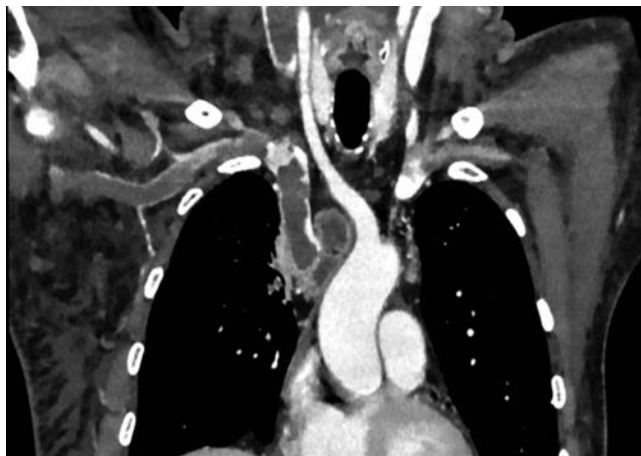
Preoperative CT showed complete right subclavian vein, brachiocephalic venous trunk and superior vena cava thrombosis.
